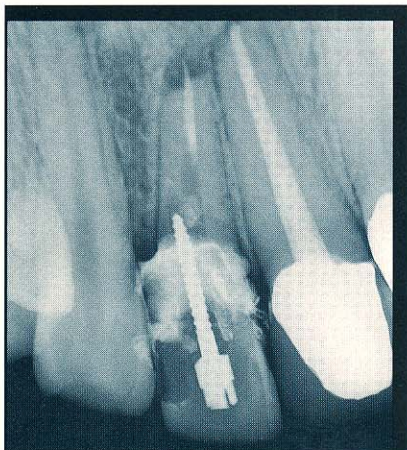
Preoperative radiograph of the lateral incisor revealed a root that had been nearly perforated by a misangulated post. A periapical radiolucency was also evident.
